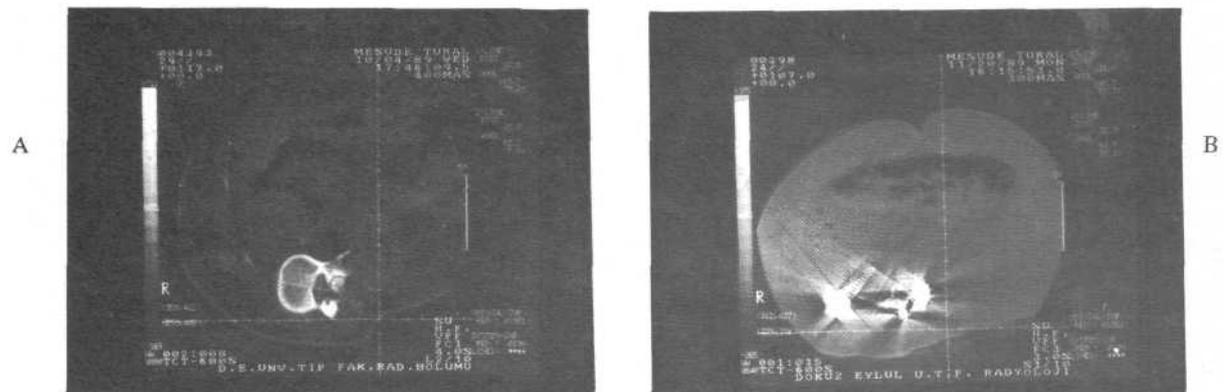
A: Single slice CT scan is obtained through the apical vertebra preoperatively.
